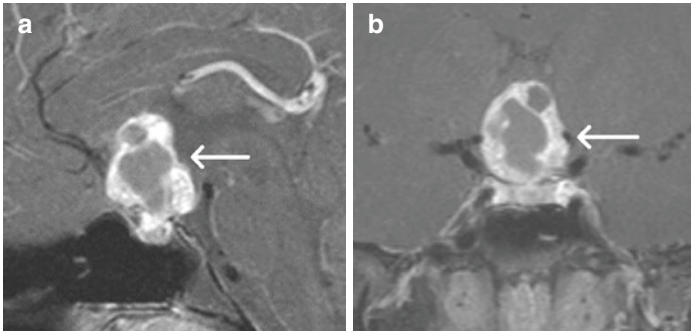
Craniopharyngioma (CP) MRI images of a 6-year-old girl with CP. (a) Postcontrast sagittal T1 with fat saturation image. (b) Postcontrast coronal T1 with fat saturation showing mixed cystic and solid mass with heterogeneous enhancement extending to the suprasellar region (straight white arrow)
